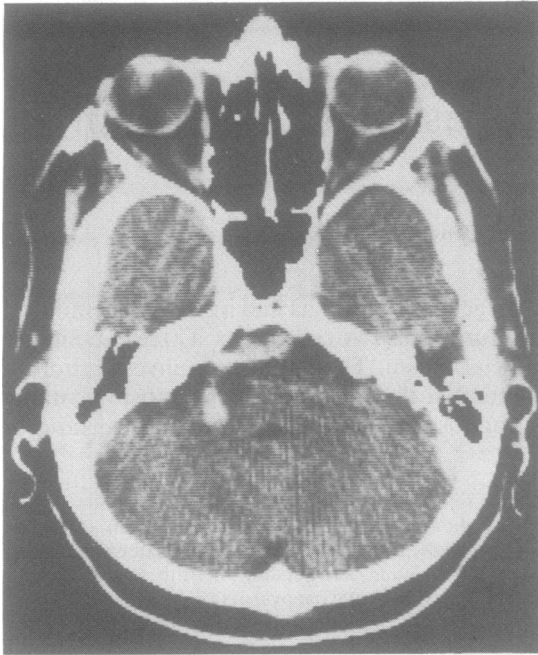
Fig CT scan, after contrast, showing an ectatic and looped left vertebral artery.
